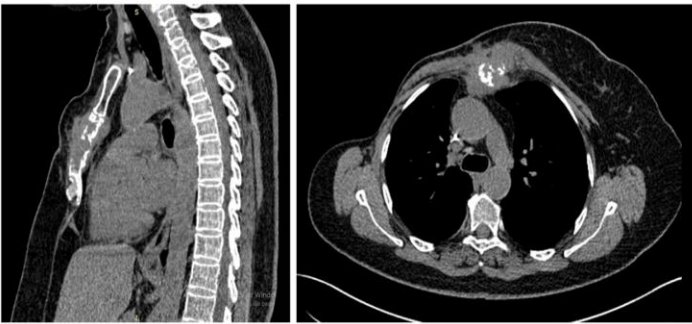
Computed tomography of the thorax shows a soft tissue mass with manubrial destruction.
